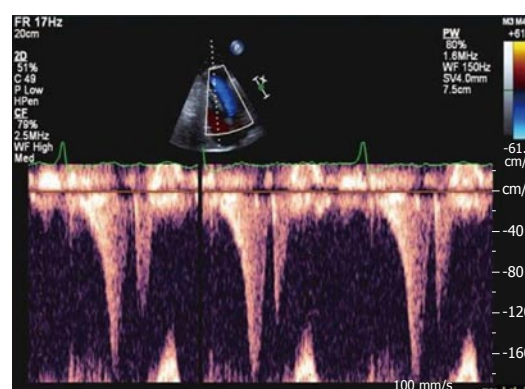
Doppler imaging showing a late peaking systolic gradient.
